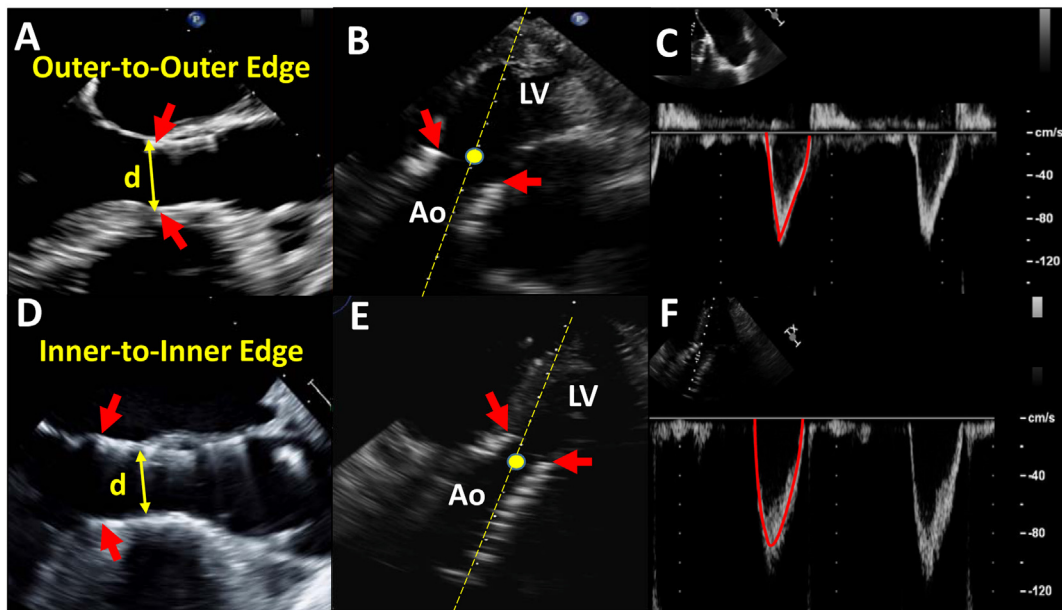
Calculation of flow in the left ventricular outflow in transcatheter aortic valves. The default approach is to measure LVOT diameter using the outer edge-to-outer edge diameter at the lower (ventricular) end of the valve stent (A, arrow). The PW sample volume from the apical view is placed immediately proximal to the site of flow acceleration at the inlet to the stent (B). Stroke volume is then calculated as usual, assuming a circular LVOT geometry as $0.785 \times d^2 \times \text{VTI}$. In instances in which a self-expanding valve is placed low in the left ventricular outflow, particularly if the lower end of the stent is not in close proximity to the anterior mitral leaflet and interventricular septum, an alternative approach is to measure the inner edge-to-inner edge diameter of the valve stent immediately proximal to the cusps (D). Then, the Doppler sample volume should be placed just inside the stent but proximal to the site of flow acceleration at the valve cusps (E). Velocity and VTI would be larger if the PW Doppler sample volume is placed just inside the stent (F vs C). Note that with transcatheter valves, there is flow acceleration at the inlet to the stent and again at the valve cusps. Red arrows point to the lower end of the stent. Ao, Aorta; LV, left ventricle.
